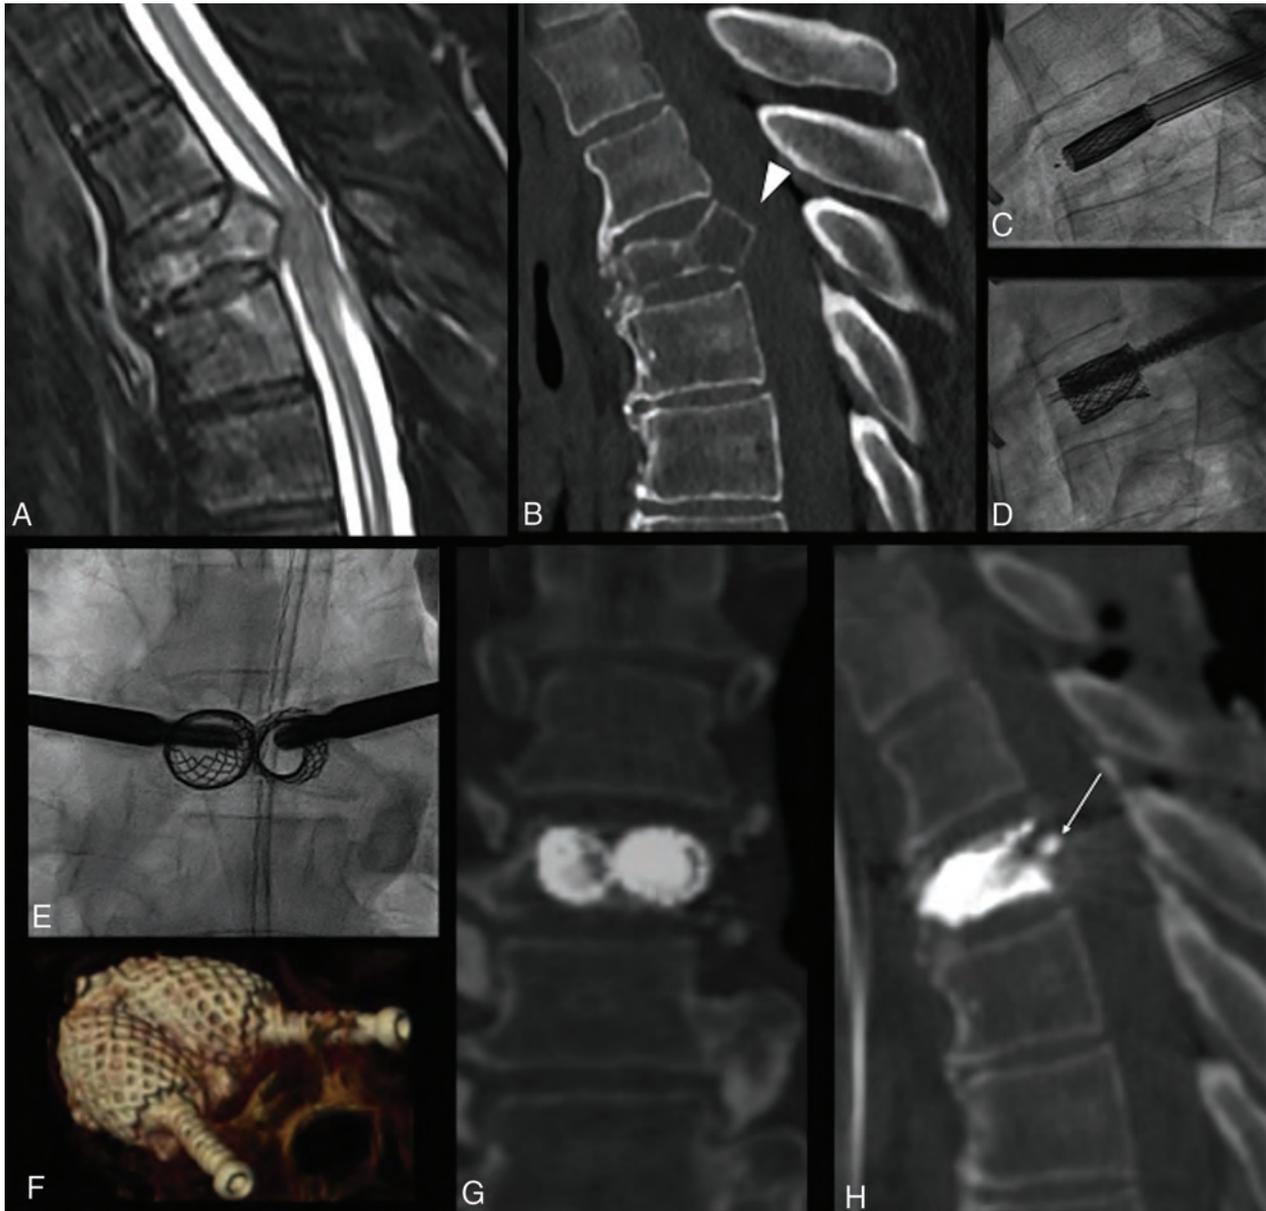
Lung cancer metastatic T4 fracture in a 67-year-old man, with disabling back pain. MR imaging (A) and CT (B) show a lytic lesion, with vertebral body collapse and retropulsion of an osseous fragment (*arrowhead*, B), causing spinal cord compression, but the patient was neurologically intact. The patient underwent armed kyphoplasty with the SAIF technique (C–E) with bilateral stent and screw implant, with a decompressive surgery backup plan on standby. The procedure was uneventful, and the patient showed no neurologic worsening. Postoperative CT (F–H) shows a 3D view of the stent-screw-cement complex (F) and, most notably, the vertebral body height restoration and correction of posterior wall retropulsion (*arrow*, H) through ligamentotaxis. The patient was ambulating the same day and could undergo radiation treatment during the following days.
